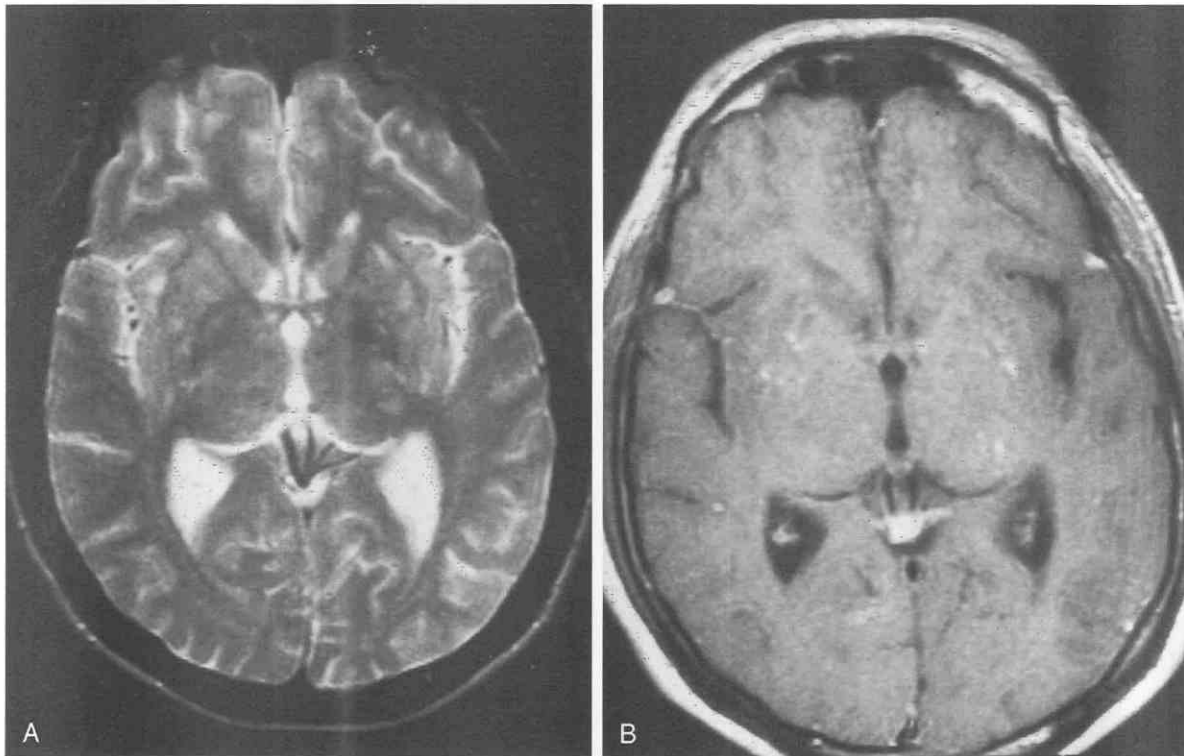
Cryptococcosis meningitis. A, T2-weighted image shows multiple small high-signal-intensity areas in the basal ganglia, consistent with a dilated Virchow-Robin space. B, Gadolinium-enhanced MRI study demonstrates small nodular enhancement, corresponding to the high signal intensity seen on T2-weighted images.
